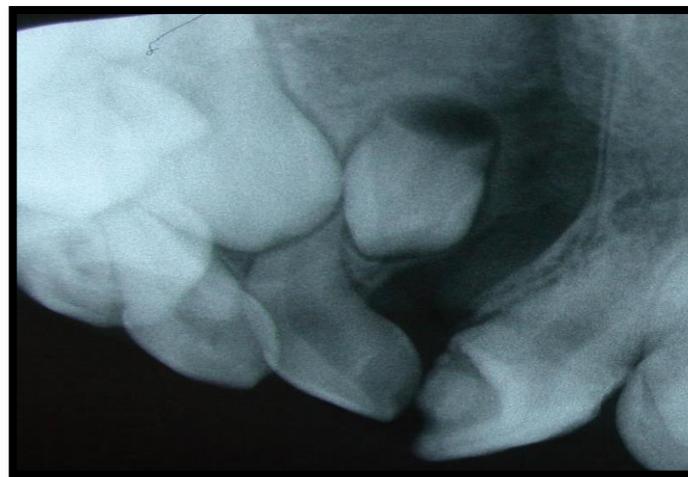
A. Periapical x-rays before
